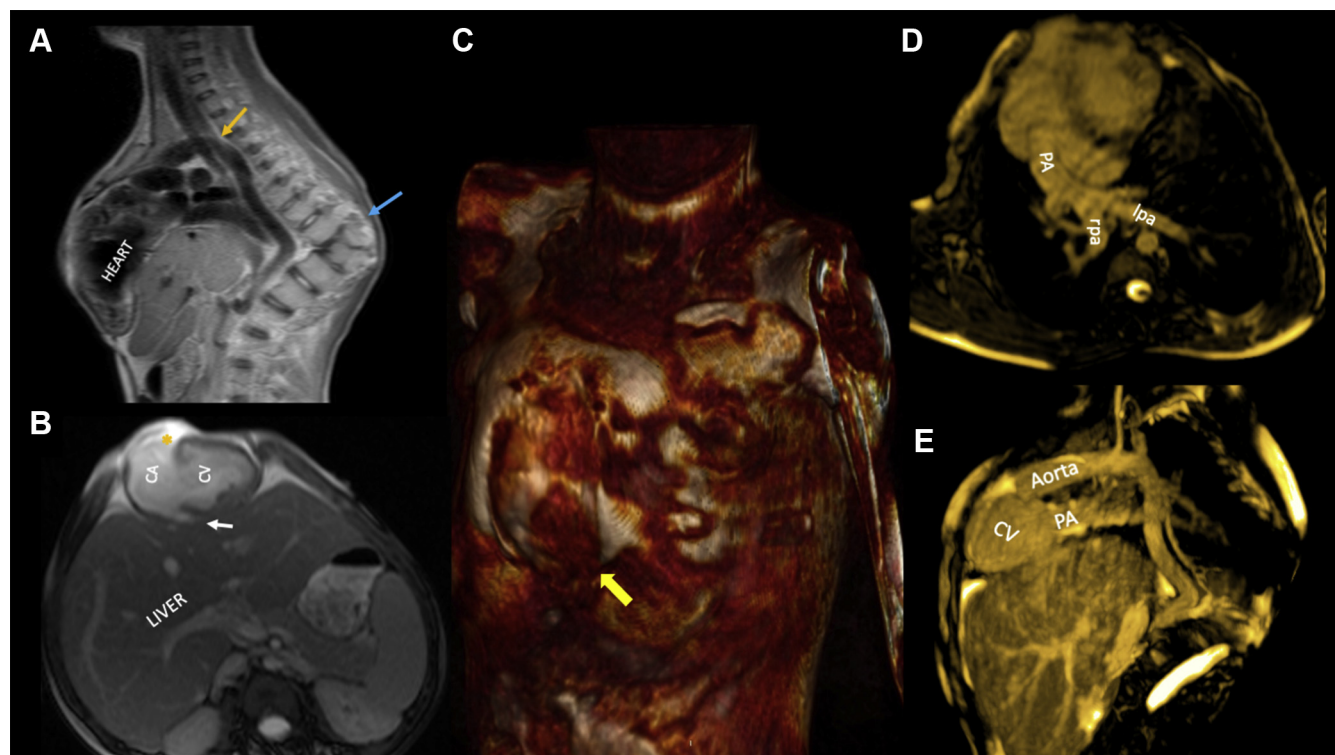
(A) Cardiac magnetic resonance. T1-sequence MRI in sagittal view showed tortuosity in the aorta (yellow arrow), ectopia cordis and severe kyphosis of the thoracic column (blue arrow). (B) T2-weighted sequences presenting atrial situs solitus (right and left atrial appendages marked with an asterisk and white arrow) with a common atrioventricular valve and single ventricle, central liver, and loss of the continuity of the anterior thoracic wall due to the absence of the sternum. (C) Three-dimensional (3D) volumetric reconstruction showed a thoracic mass corresponding to the ectopic heart. (D) 3D navigator in axial view evidenced the main pulmonary artery and its branches. (E) 3D navigator in sagittal view confirmed the tortuosity in the aorta and showed the outlet of the main pulmonary artery, both arising from the single ventricle. CV, common ventricle; LPA, left pulmonary artery; PA, pulmonary artery; RPA, right pulmonary artery.
